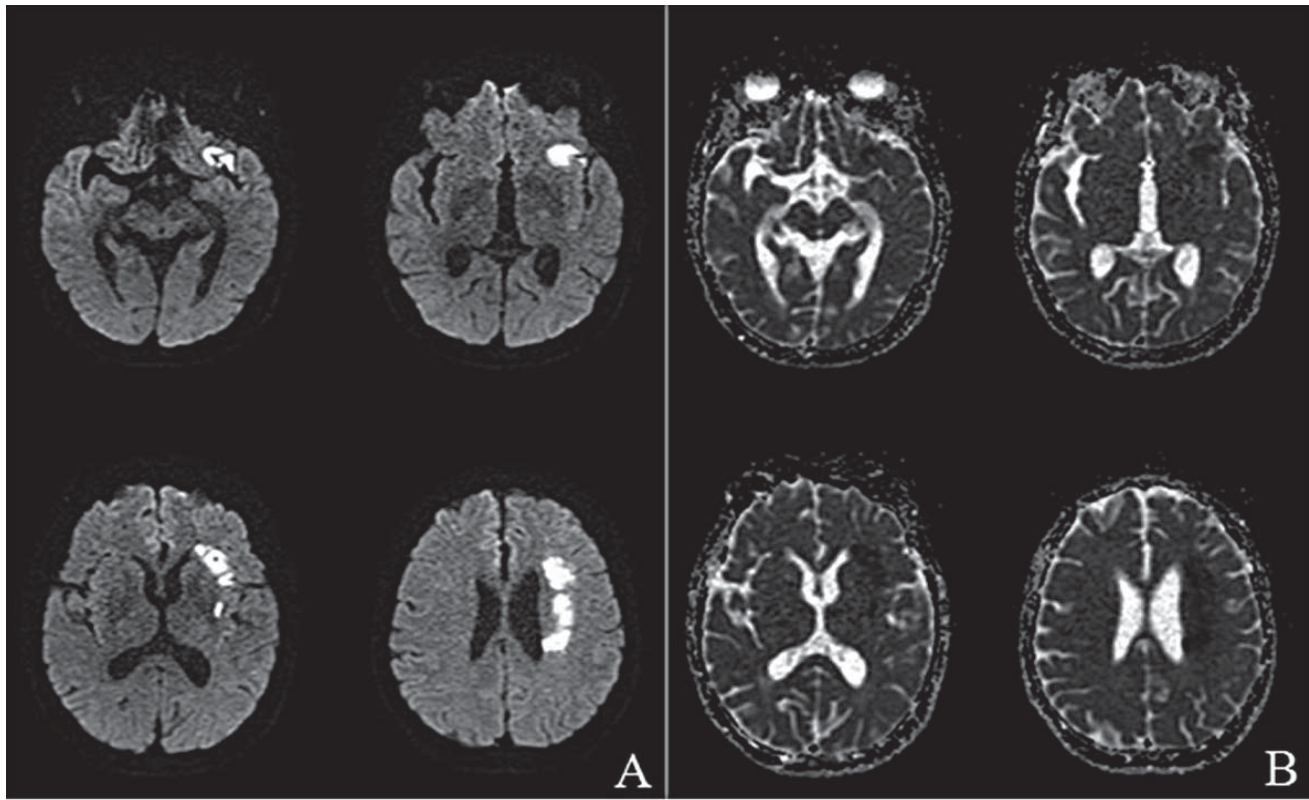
Diffusion-weighted magnetic resonance images (A) show hyperintensity over the left centrum semiovale, corona radiata, insular ribbon, and peri-fissural frontal lobe, consistent with the area of hypointensity in magnetic resonance apparent diffusion coefficient maps (B). The regions mentioned above indicate acute infarction lesion.
